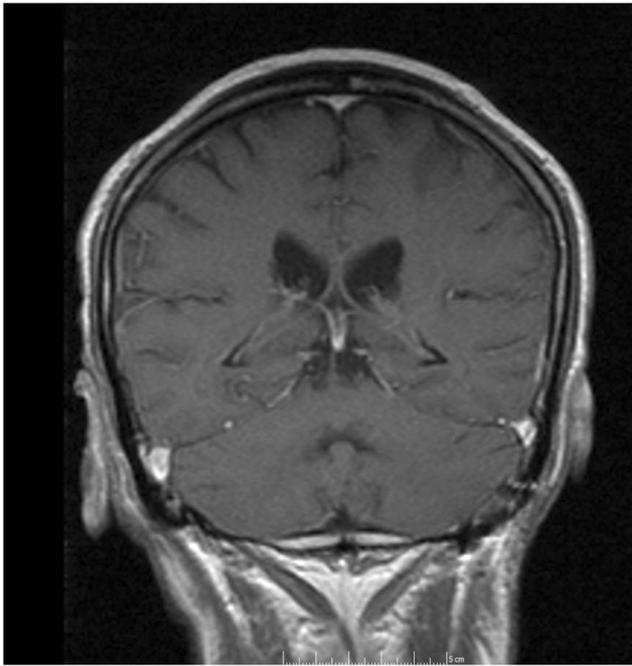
Resolution of leptomenigeal enhancement. Imaging 3 months into treatment for nasopharyngeal carcinoma. Coronal T1-weighted imaging after the intravenous administration of contrast demonstrates resolution of the enhancement of the cerebellar hemisphere surfaces and the cranial nerves. Post-contrast FLAIR also revealed no leptomenigeal enhancement
